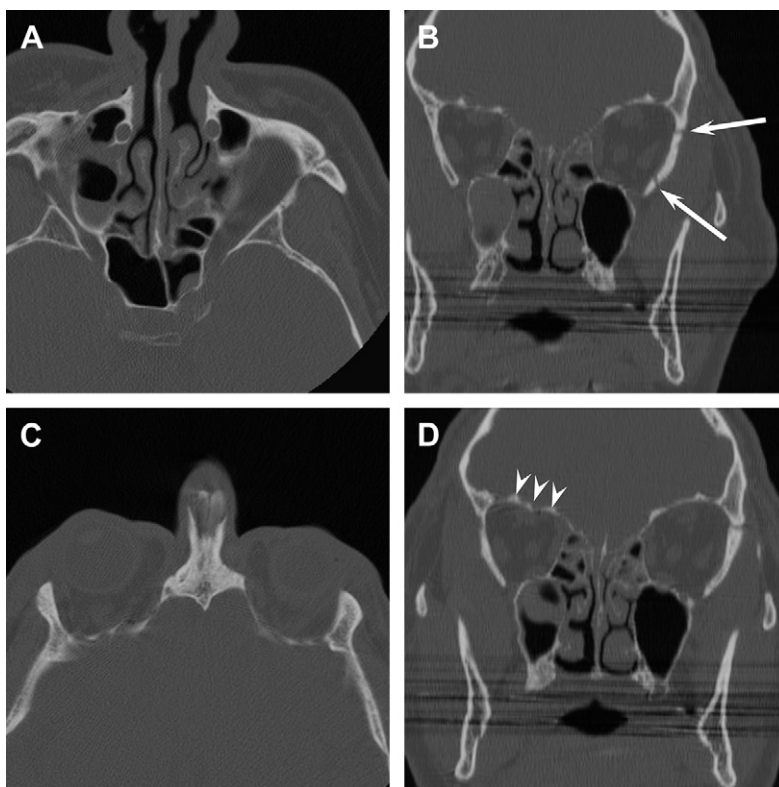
Utility of CT postprocessing in the evaluation of orbital fractures. (A) Axial CT through the orbits does not identify any orbital fractures. (B) Coronal reformatted image clearly shows the two fractures (*arrows*) of the left orbital wall. (C) Axial CT in another patient demonstrates apparent symmetry between the orbital roofs. (D) Coronal reformatted image shows the depressed fracture of the right orbital roof (*arrowheads*).
